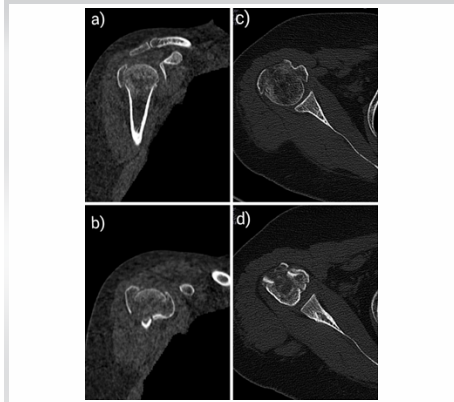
CT scan sagittal cuts (a and b) and axial cuts (c and d) showing greater and lesser tuberosity fragments with head shaft continuity.
